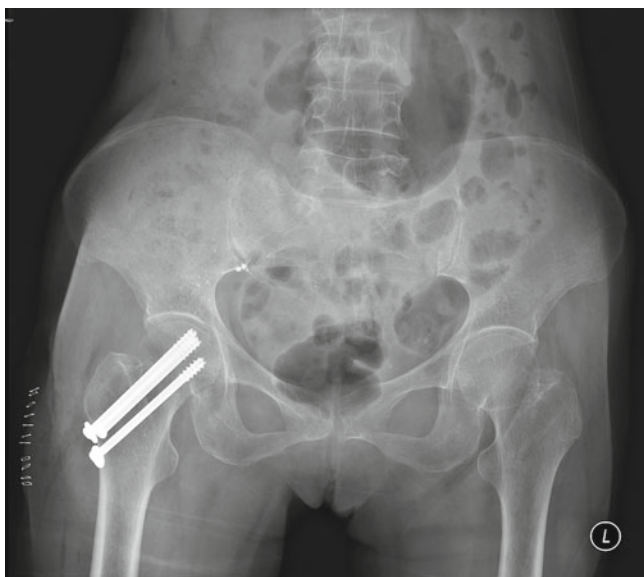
AP pelvis X-ray of percutaneous screws for fixation of a valgus-impacted femoral neck fracture
